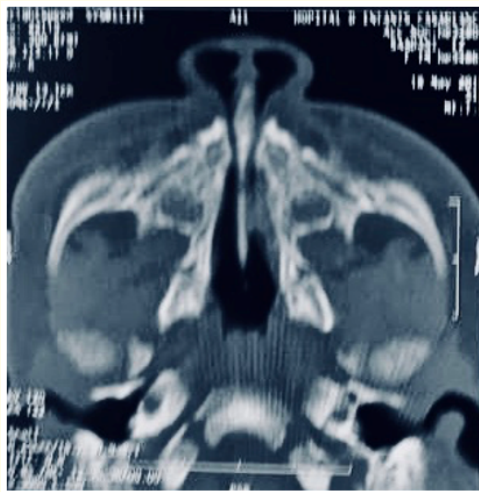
The CT scan, non-complete stenosis of the nasal pyriform aperture. The choanal opening were normal.
